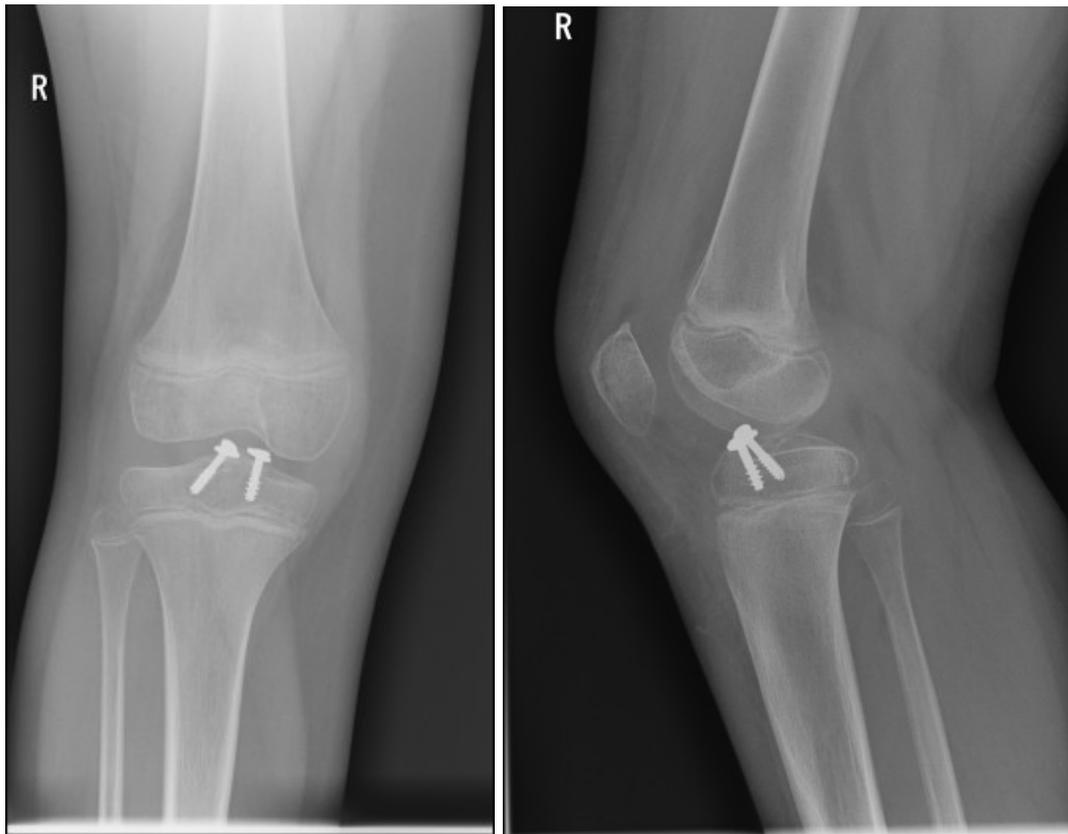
Postoperative X-Ray images (4 month after surgery) showing a healed fracture with 2 cannulated epiphyseal screws and washers)
